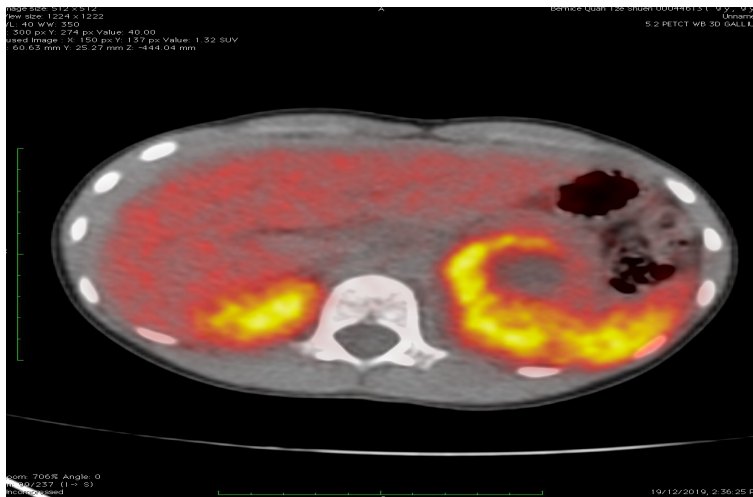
Focal of Ga-68 DOTATATE uptake seen at the left suprarenal mass (SUVmax 14.5) likely to arise from the left adrenal gland measuring 2.8 x 1.9 cm
